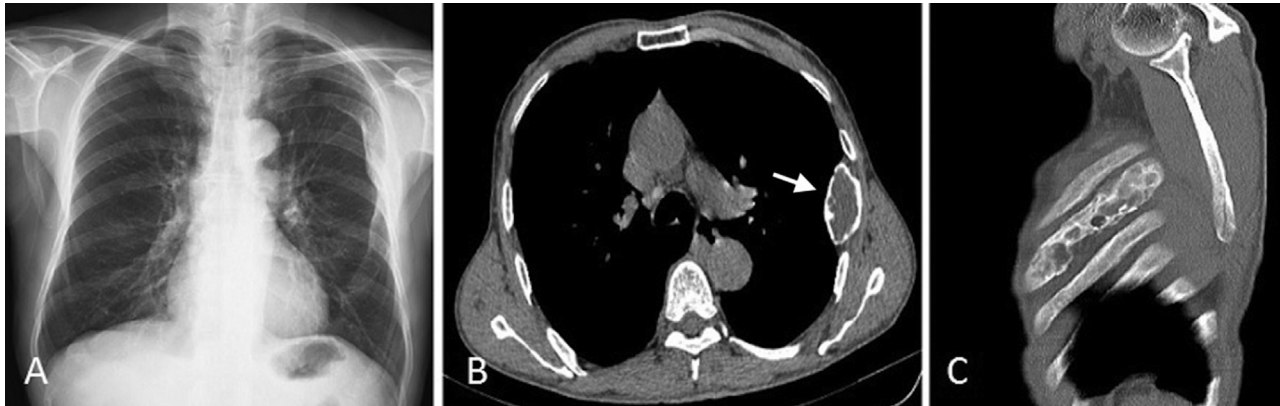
Preoperative radiographic images of the lesion. (A) Chest radiograph shows an expansile mass of 4.5 cm in diameter. (B) Axial computed tomography image shows an expansile lytic lesion (arrow). (C) Sagittal computed tomography image demonstrates an expansile mass that occupies almost the entire length of the sixth rib.
